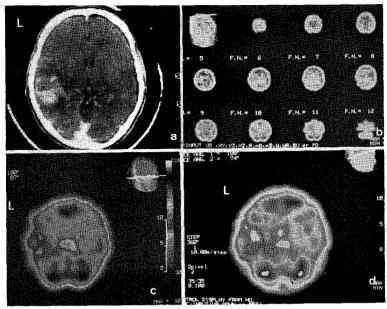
Brain CT showing a large intracerebral hematoma in left temporal lobe (a). Tc-99m-HMPAO brain SPECT showing inhomogeneous perfusion defect involving parietotemporal lobe (b & c). Follow-up Tc-99m-HMPAO brain SPECT after bypass surgery showing slight improvement of perfusion (d).
